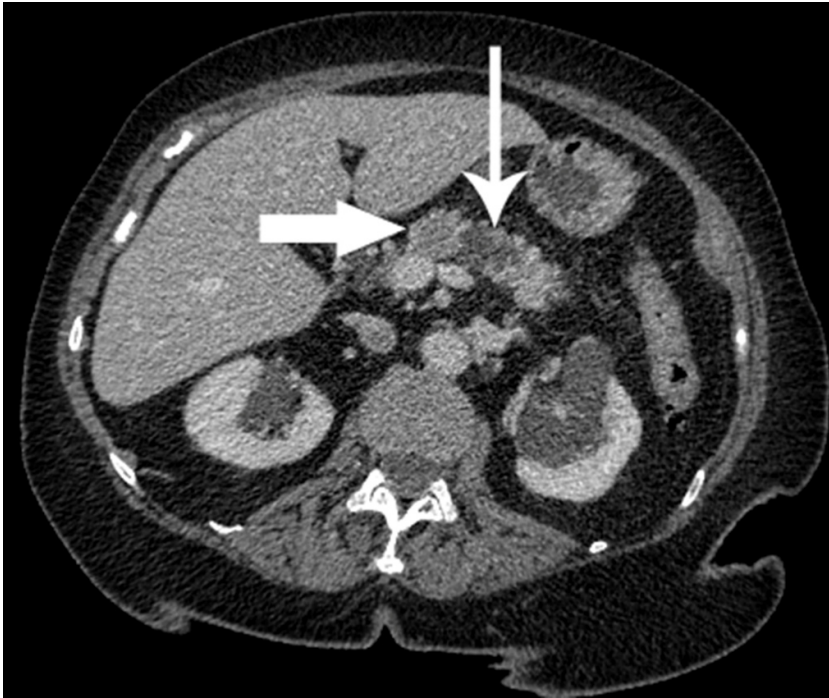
A CE-CT scan of a patient with PDAC. A hypodense, dark bulk in the body of the pancreas (thick arrow) and a dilated pancreatic duct (thin arrow). Courtesy of Dos. Irina Rinta-Kiikka, Tampere University Hospital.
